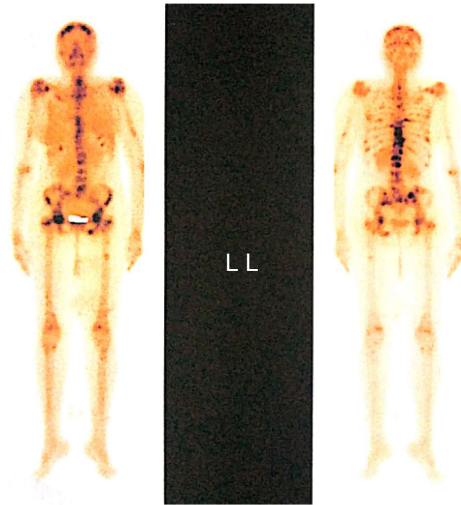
Whole body bone scan performed in 45-year-old patient with left breast carcinoma. Description of Figure 6: Whole body bone scan performed in 45-year-old patient with left breast carcinoma. There are multiple focal and intense hyperfixations localized in the skull, cervical and thoraco-lumbar spine, sternum, anterior and posterior costal arches, pelvis (iliac wings, sacrum, ilio and ischio-pubic branch) and left femur, compatible with bone metastases. We conclude that there is a scintigraphic appearance of multiple secondary bone localisations realizing diffuse malignant osteosis.
